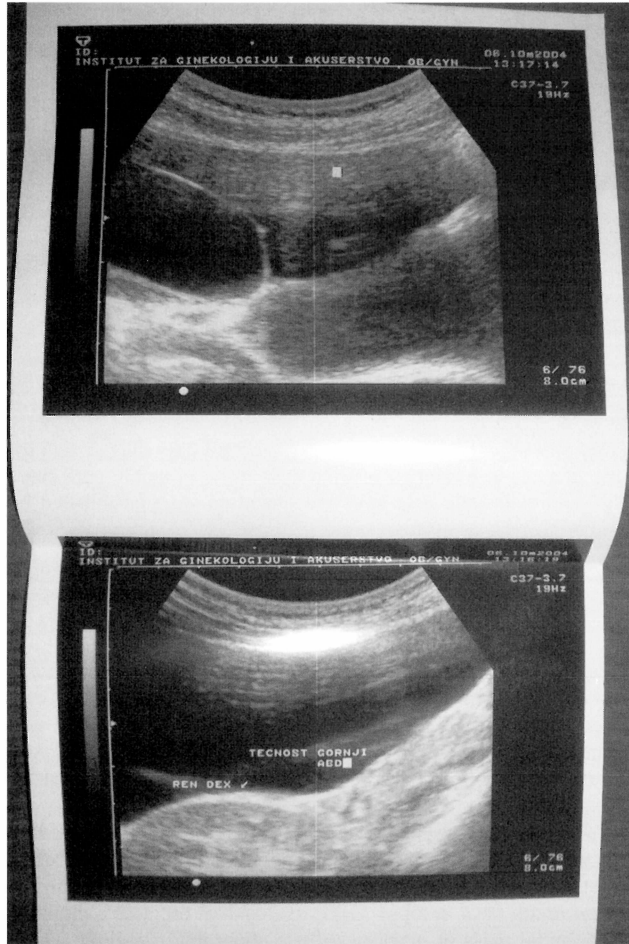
Ultrasound of carcinomatous ovarian cyst.
